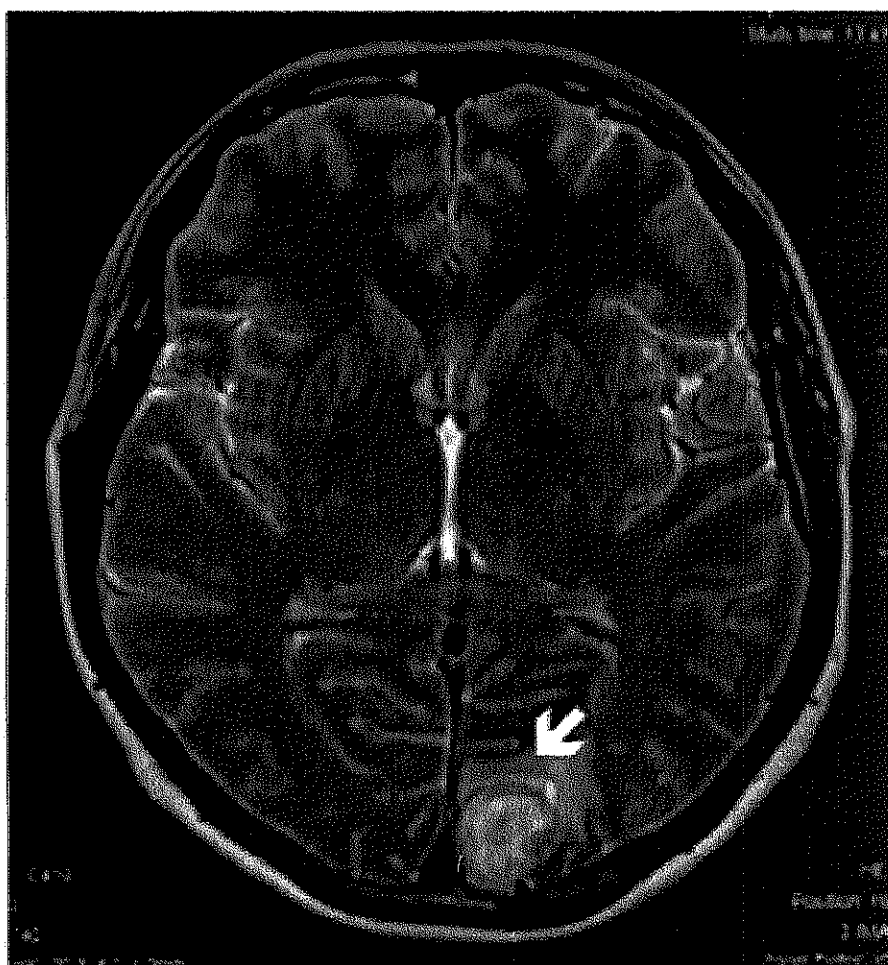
Cerebral abscesses – contrast MRI: T2 axial section, which shows a formation localized intraaxially, on the periphery of the left occipital lobe, well delineated, of approximately 20 mm with T2 hypersignal, with perilesional oedema.
